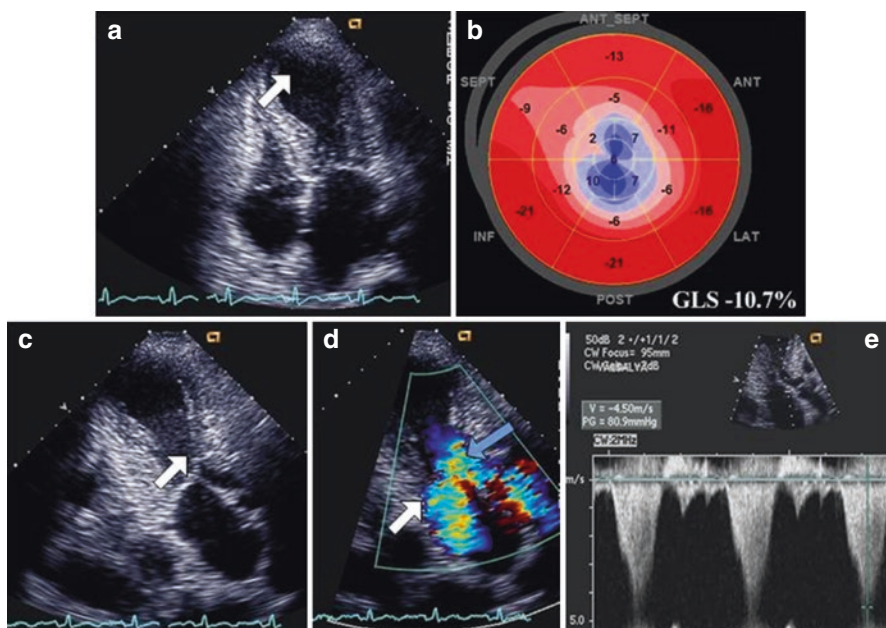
Echocardiographic findings in stress-induced cardiomyopathy. A large area of apical akinesis is seen on the end-systolic frame (panel a, arrow). Speckle-tracking echocardiography demonstrates reduction in the global longitudinal strain due to markedly decreased strain values in the apical and mid-ventricular segments (panel b). Further interrogation reveals systolic anterior motion of the mitral valve with mitral-septal contact in mid-systole (panel c). Color Doppler demonstrates characteristic V sign (panel d) due to turbulence in the left ventricular outflow tract (blue arrow) and posteriorly directed secondary mitral regurgitation (white arrow). Spectral Doppler interrogation reveals high left ventricular outflow gradient (panel e)
